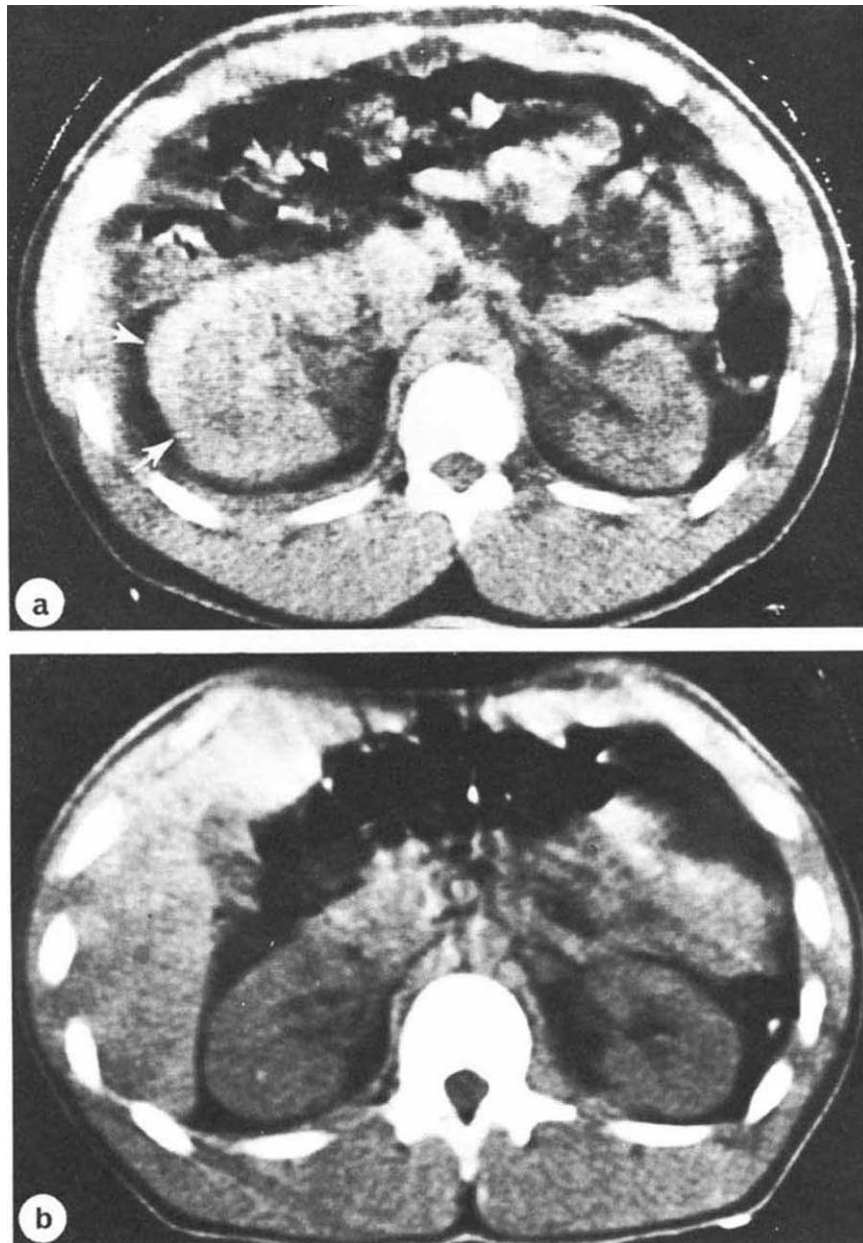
a) CT scan at the level of the midzone of the right kidney demonstrating a large perinephric hematoma (white arrows) surrounding all but the medial surface of the right kidney. Note that the density of the hematoma is slightly greater than the adjacent renal parenchyma. Compare also to the density of the left kidney. b) Follow up CT scan, 3 months after renal biopsy, demonstrating complete resolution of the right-sided perinephric hematoma.
